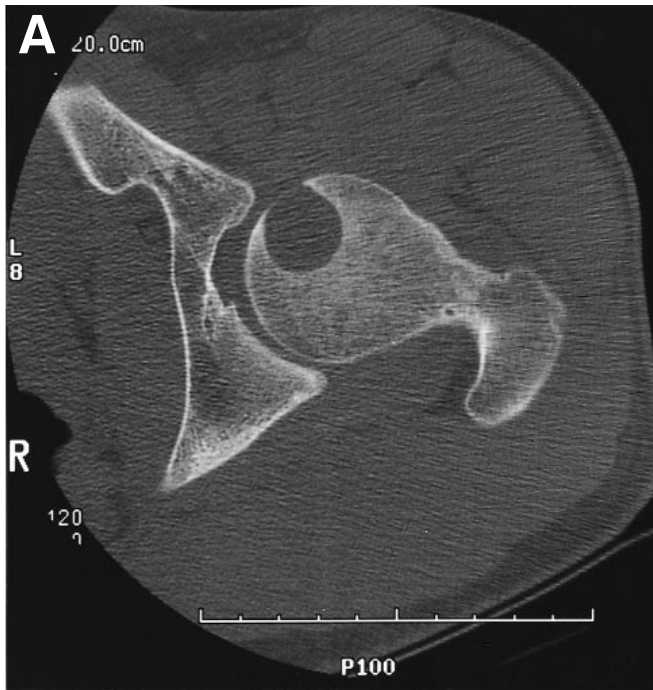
(A) Computed tomography of the femoral head of a 19-year-old patient, showing a chondroblastoma. Due to its anterior location the femoral head and neck were exposed using the Watson-Jones approach without dislocation of the femur. Curettage, burr drilling, and cryosurgery were performed. (B) These were followed by autologous iliac bone graft, reinforcement with PMMA, and internal screw fixation.
